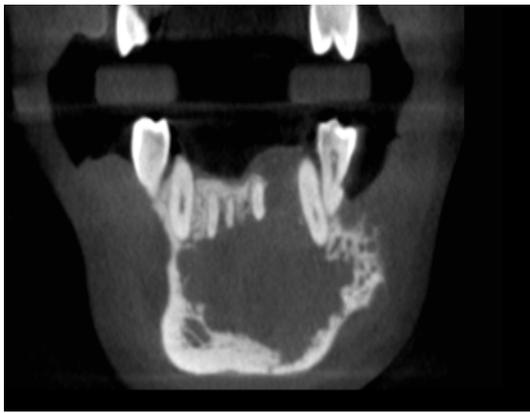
Honey comb appearance (CBCT coronal section)
